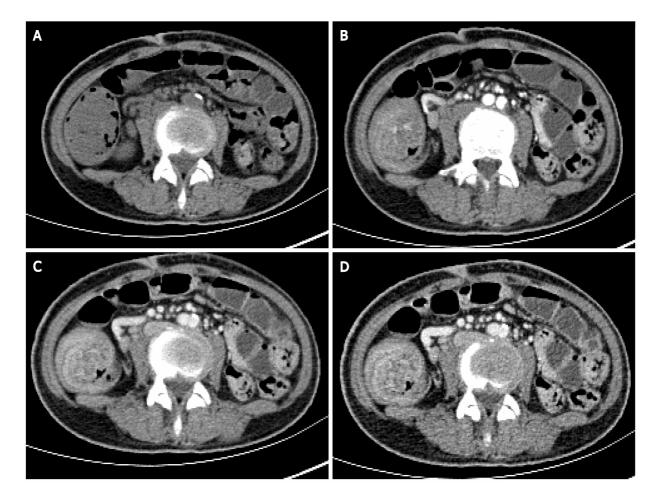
Abdominal enhanced computed tomography. Multiple concentric ring signs in the ileocecal area indicating ileocecal intussusception. A: Plain computed tomography scan; B: Arterial phase; C and D: Venous phase.
